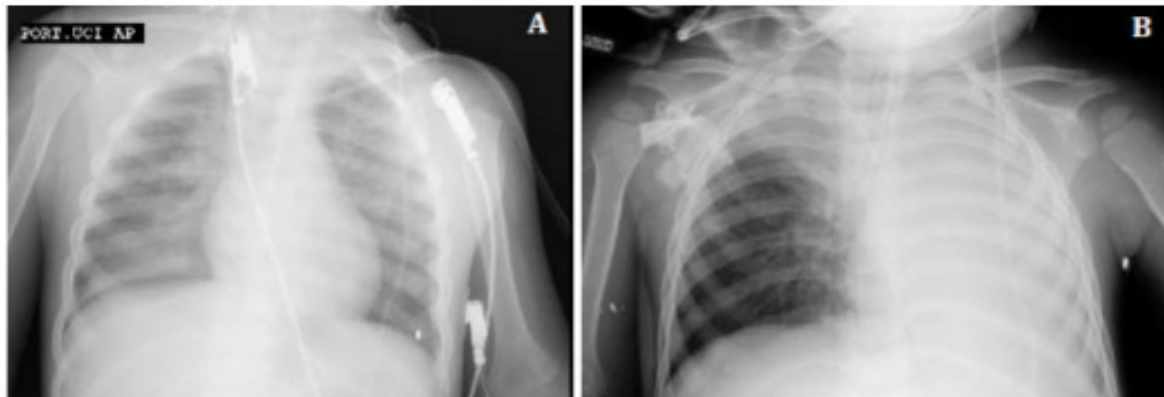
Chest radiography obtained during the clinical course. Panel A shows multilobar pulmonary consolidation, while Panel B demonstrates right pneumothorax and the position of the endotracheal tube
